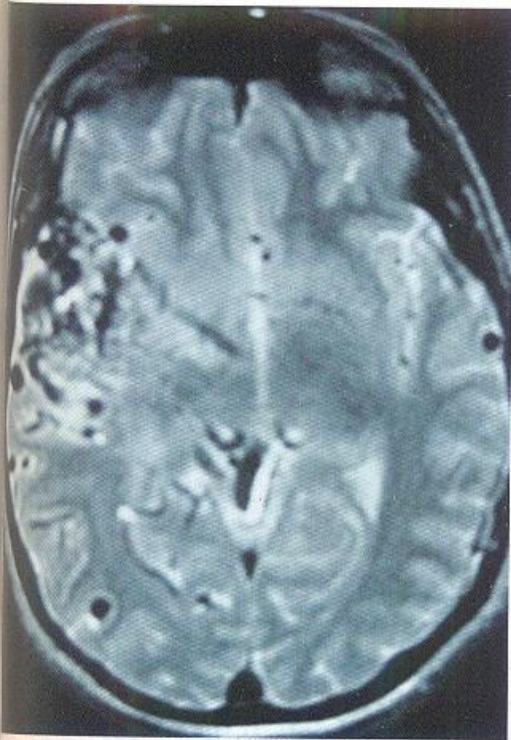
MRI showing A-V Malformation right side.
